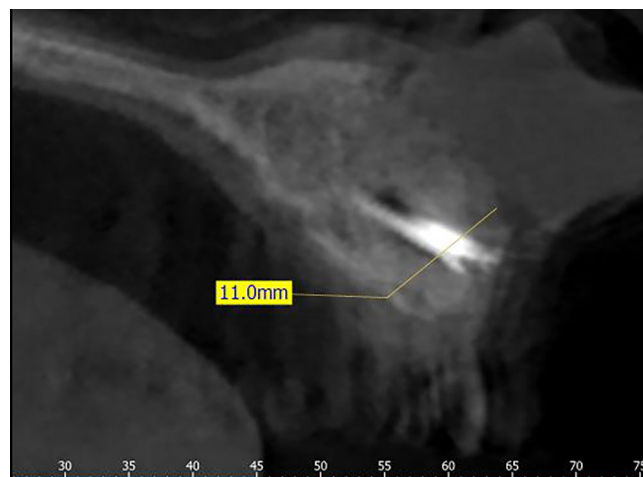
Follow-up CT scan at 4 months after augmentation show graft consolidation with excellent bone contour at the labial alveolar crest
